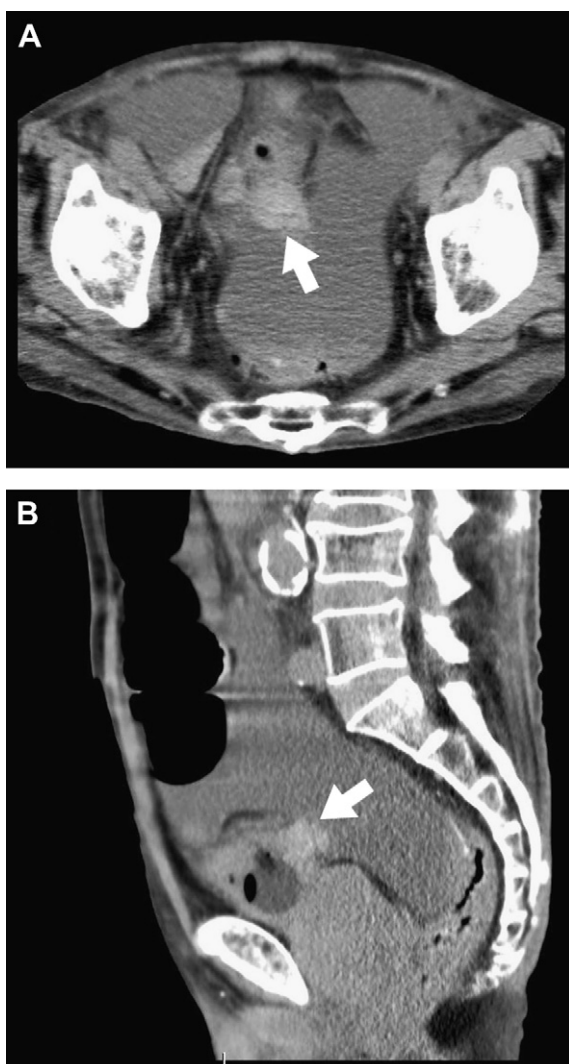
Computed tomography scan showing ruptured site of urinary bladder (arrows) and massive ascites on: (A) transaxial; (B) sagittal views.
